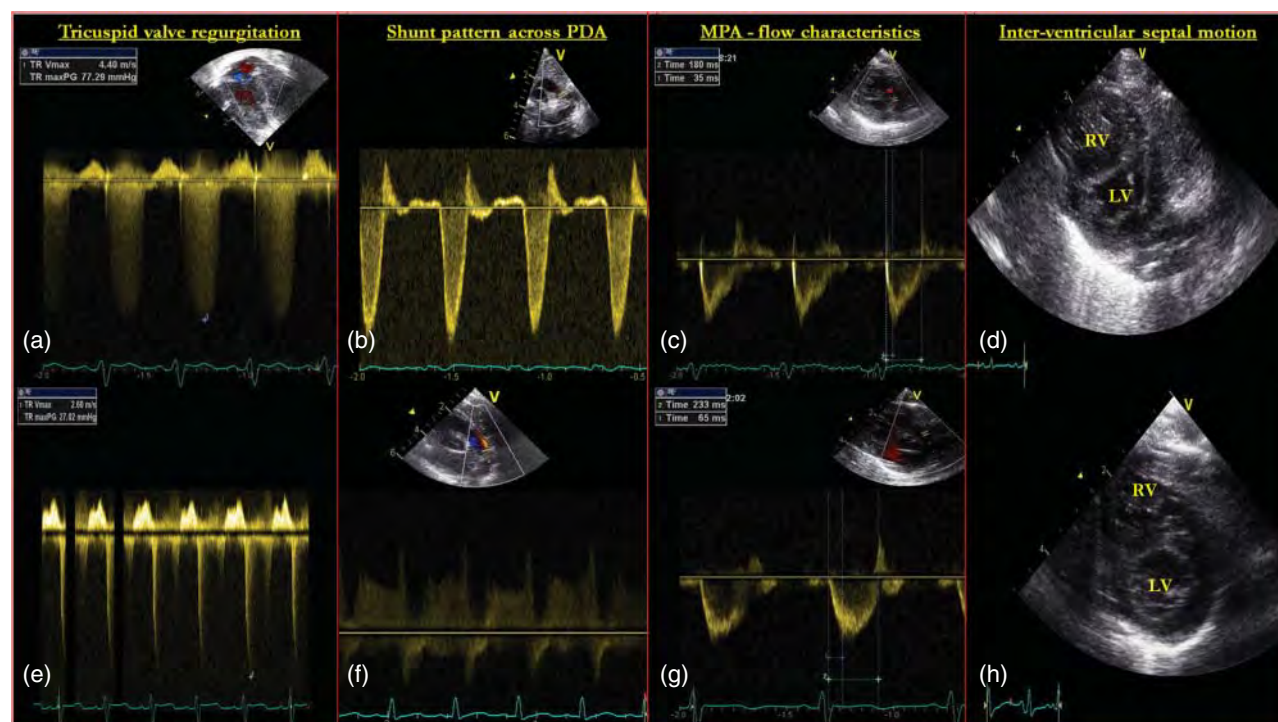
Echocardiography in an infant with PPHN before (a–d) and after successful treatment with inhaled nitric oxide (e–h). (a,e) Tricuspid regurgitation (TR) can quantify peak systolic pressure gradient across tricuspid valve (TRmaxPG). Peak systolic pulmonary artery pressure = TRmaxPG + estimated right atrial pressure. (b,f) Doppler of patent ductus arteriosus (PDA). In (b), the majority of shunting is from the main pulmonary artery to aorta during systole indicated by Doppler flow below the reference line (away from the transducer), suggesting suprasystemic systolic pulmonary artery pressure. (c,g) Doppler of the main pulmonary artery. Pulmonary artery acceleration time (PAAT, time 1 in figures) and right ventricular ejection time (RVET, time 2 in figures) can indirectly estimate pulmonary vascular resistance (PVR). High PVR is associated with short PAAT and high RVET : PAAT ratio. (d,h) Qualitative appraisal of the curvature of the interventricular septum in systole. The ‘flat’ septum in (d) indicates at least half systemic right ventricular (RV) pressure. Following treatment, the septum assumes a more leftward concavity (h) suggesting lower RV pressure.
